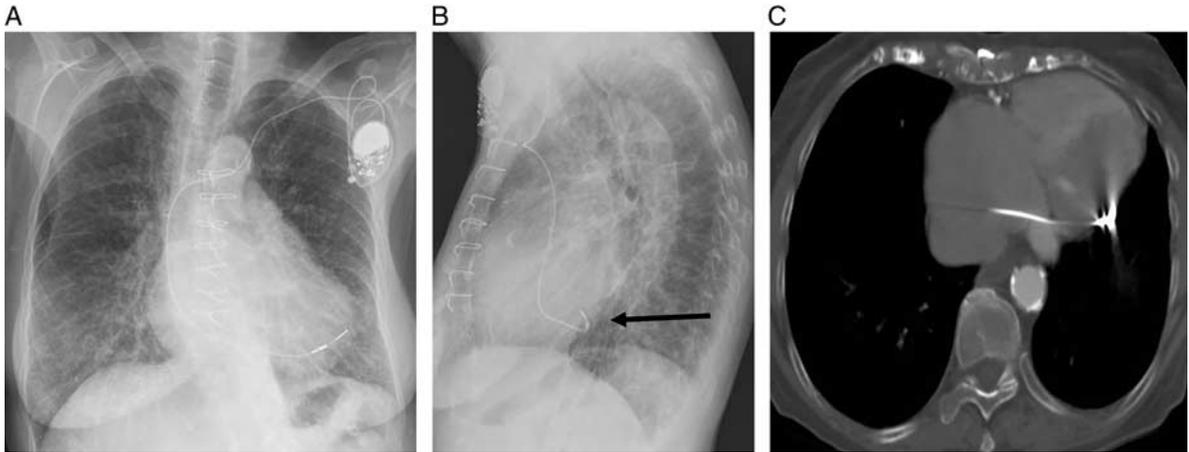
Perforated pacemaker lead: frontal (A) and lateral (B) radiograph as well as an axial CT image (C) depicting a perforated pacemaker lead (black arrow) coursing via the coronary sinus into the left lateral pericardial space.
